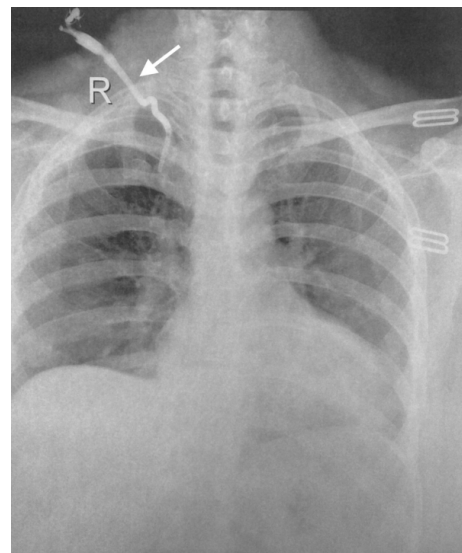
Chest X-ray demonstrating the path of the catheter (arrow)
